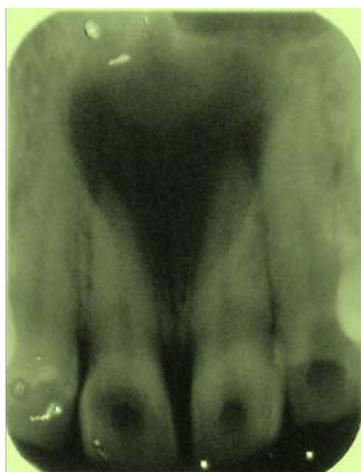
Showing Heart Shaped radiolucency in the periapical region of 11 and 21
